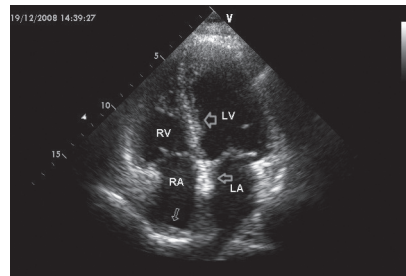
TTE, Apical four-chamber view demonstrating cardiac calcium depositions in right atrium, interatrial and interventricular septum
